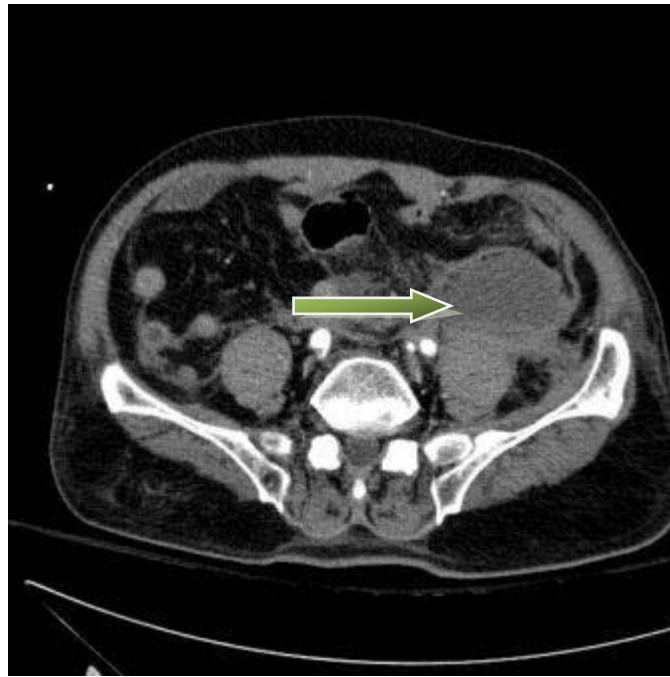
lower cuts of the contrast enhanced CT scan showing the extension of the retroperitoneal haematoma into the lower pelvis (the green arrow)
